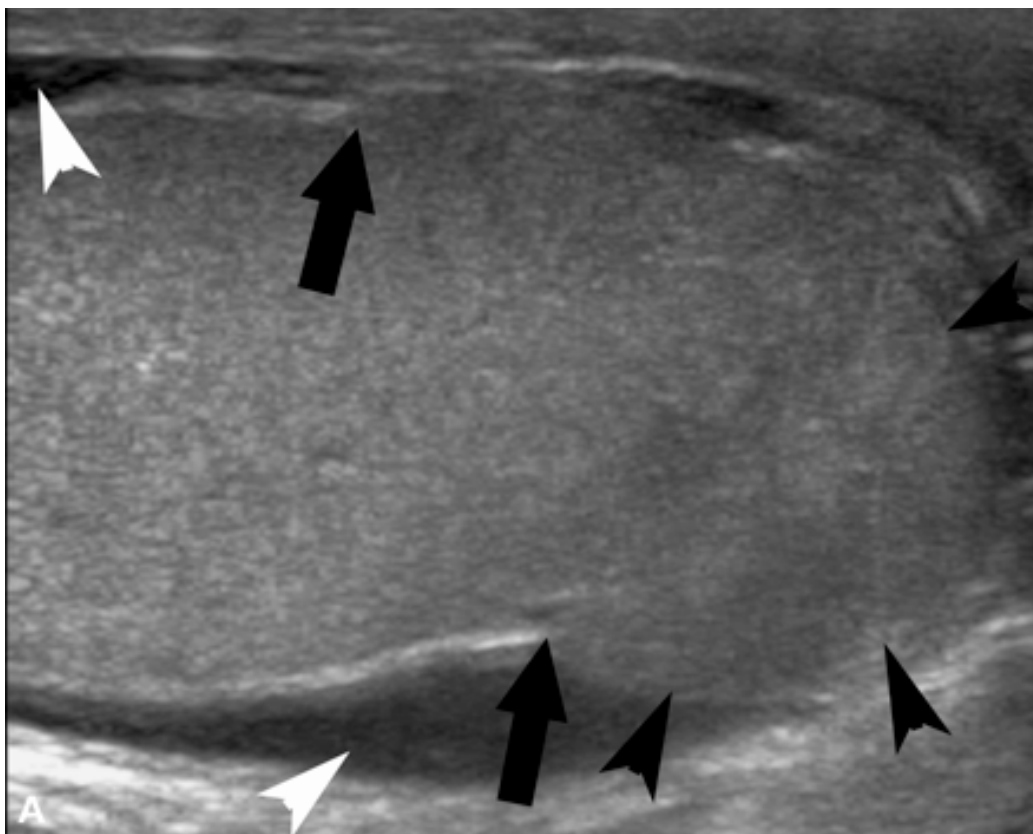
This is a longitudinal sonography showing a loss of definition (arrows) of the tunica albuginea and an extruding heterogeneous hypoechoic lesion (black arrowheads) representing the seminiferous tubules. A surrounding hematocoele is also show (white arrowheads). (www.jultrasoundmed.org)
